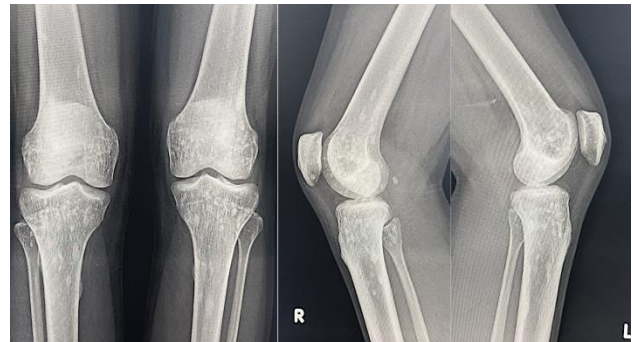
Bilateral knee radiograph.
